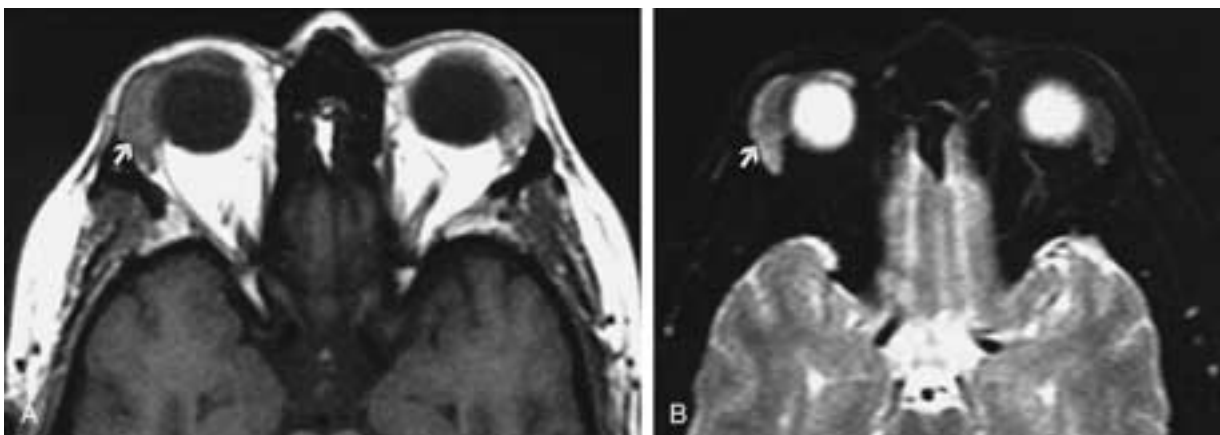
Pseudotumor. Axial T1-weighted MR (A) and axial T2-weighted MR (B) images. The right lacrimal gland is enlarged (arrows). The peripheral portion of the gland becomes brighter in the T2-weighted MR images, mimicking a lymphoma. (From Valvassori GE et al. Imaging of orbital lymphoproliferative disorders. *Radiol Clin North Am* 1999;37:135–150.)
